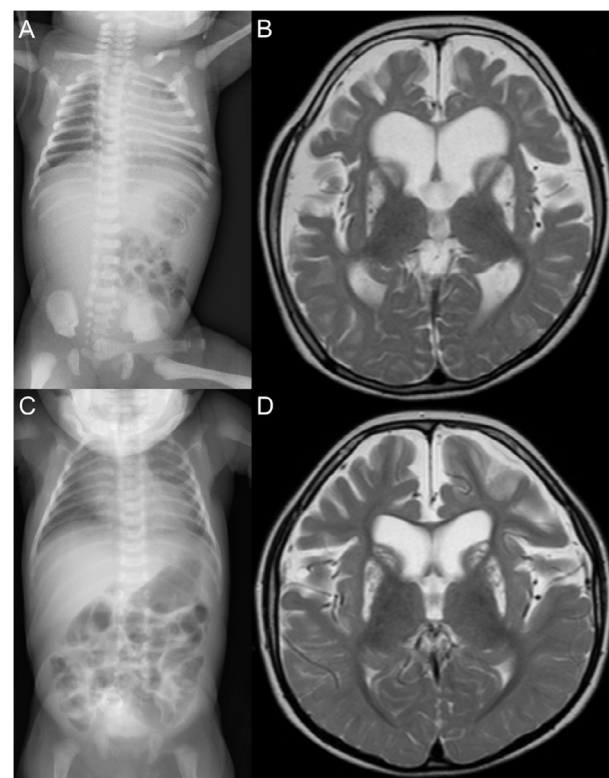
X-ray and brain magnetic resonance imaging of the patients. (A) Radiographs of the trunk (Patient II-1). (B) T2-weighted brain magnetic resonance imaging at 21 months (Patient II-1). (C) Radiographs of the trunk (Patient II-2). (D) T2-weighted brain magnetic resonance imaging at 18 months (Patient II-2).
